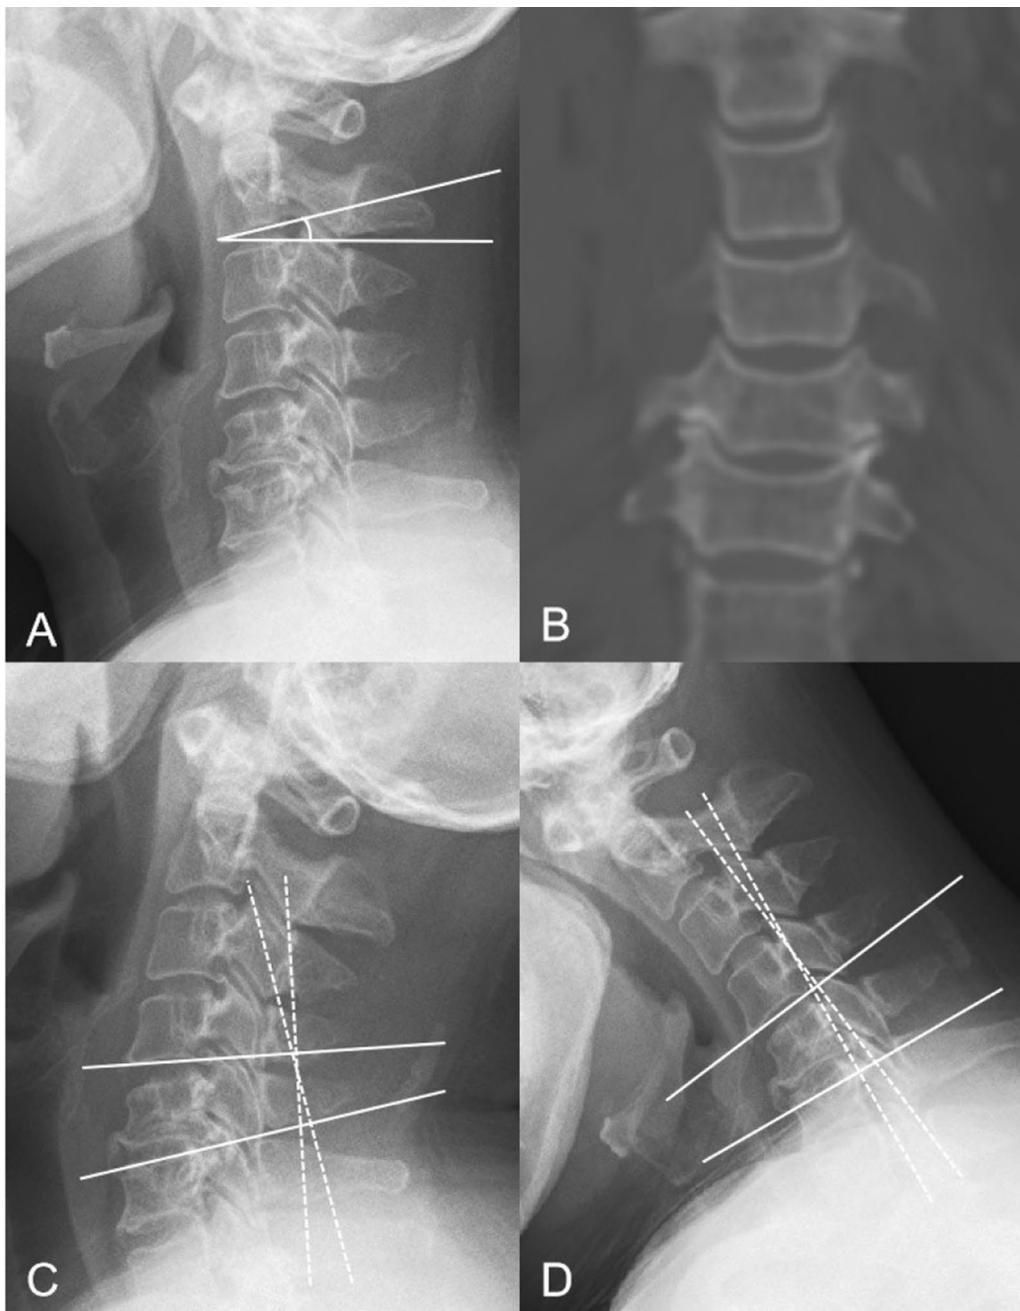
Representative preoperative images of case that achieved fusion. Radiographic parameters of the case presented in Fig. 3A. A Preoperative C2S was 17.8°, B the UVJ degeneration grade was 8 (C4-5 left: Grade 1; C4-5 right: Grade 1; C5-6 left: Grade 3; C5-6 right: Grade 3) and C-D segment ROM was 15.1°
